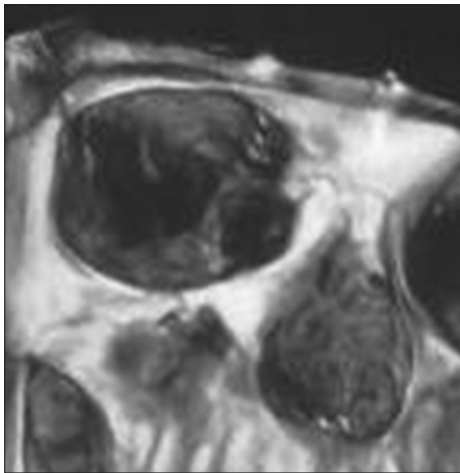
Pre surgical radiograph (Diagnostic)
